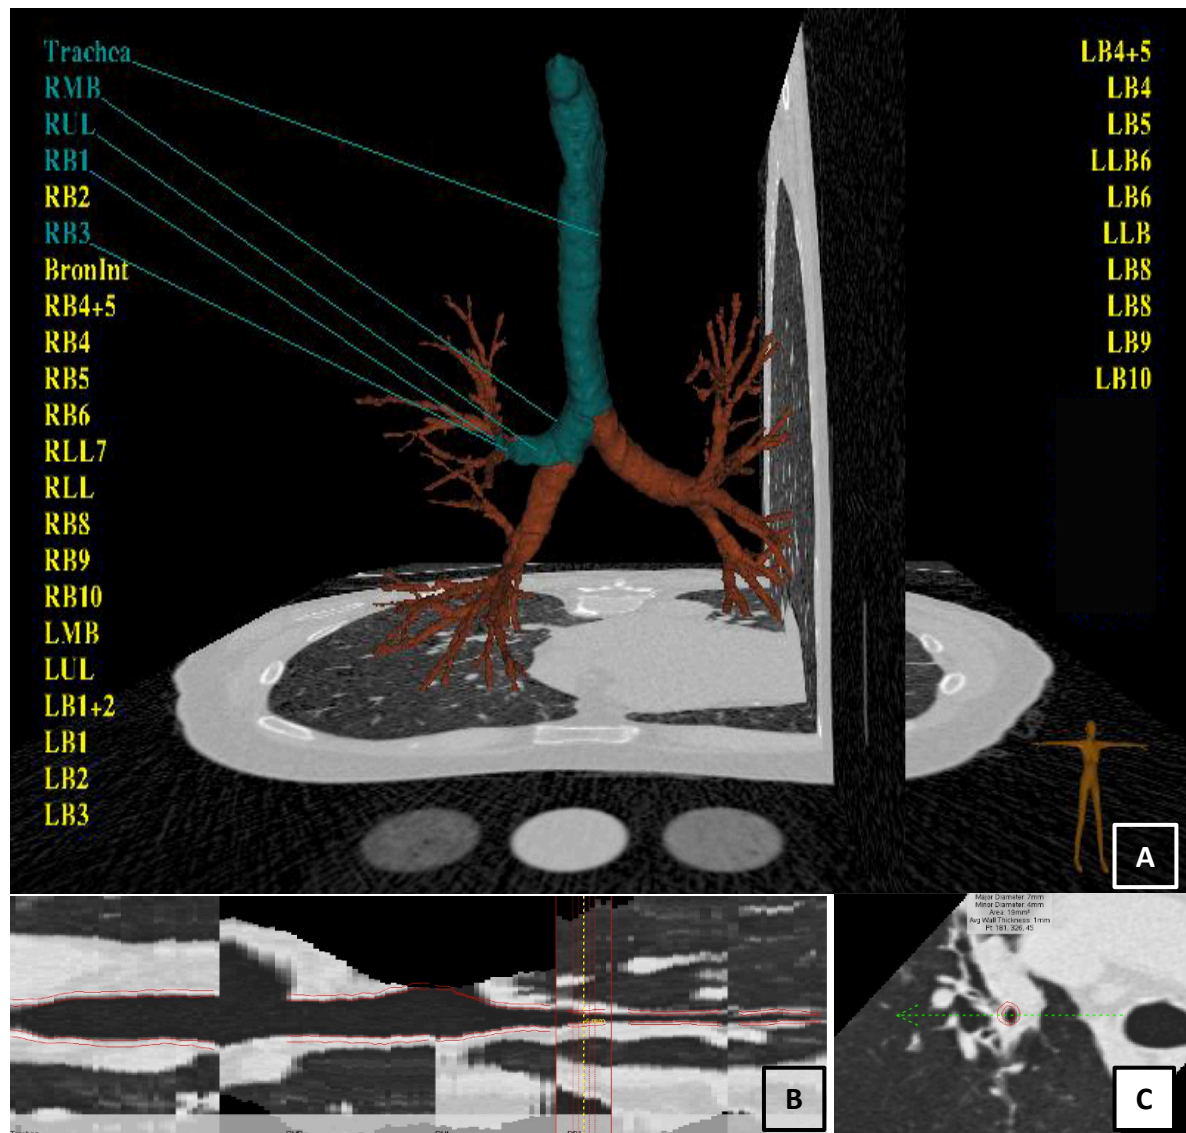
Bronchiectasis: CT diagnostic criteria
